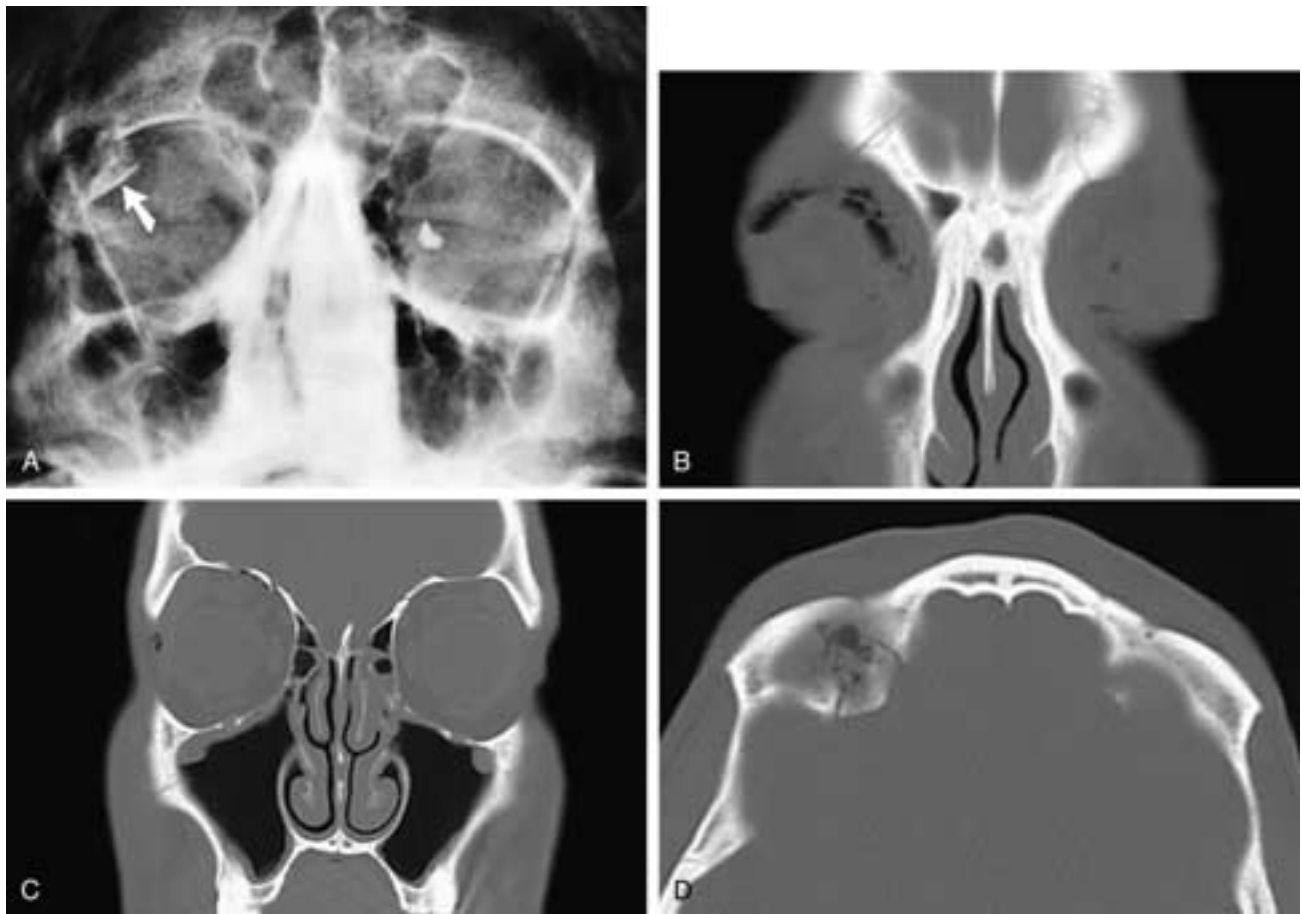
Waters view (A) shows a depressed orbital roof fracture (*arrow*) that impinged on the globe and clinically mimicked a blow-out fracture of the orbital floor with entrapment. A foreign body is also seen in the left eye. Coronal anterior (B) and posterior (C) and axial (D) CT scans on another patient with a fracture of the right frontal bone and orbital roof. There is minimal displacement of the right orbital roof fracture, as well as orbital emphysema and a small amount of extradural air. There is also a similar nondisplaced left frontal and orbital roof fracture.
